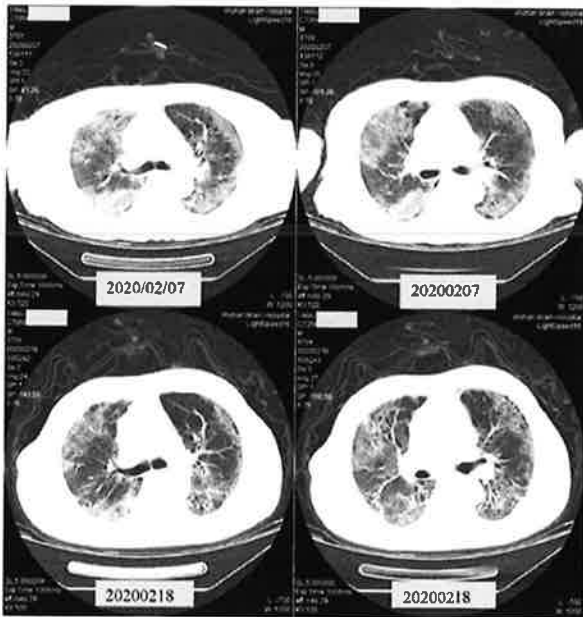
Comparison of CT before treatment (February 7) and after the 8th treatment (February 18)
